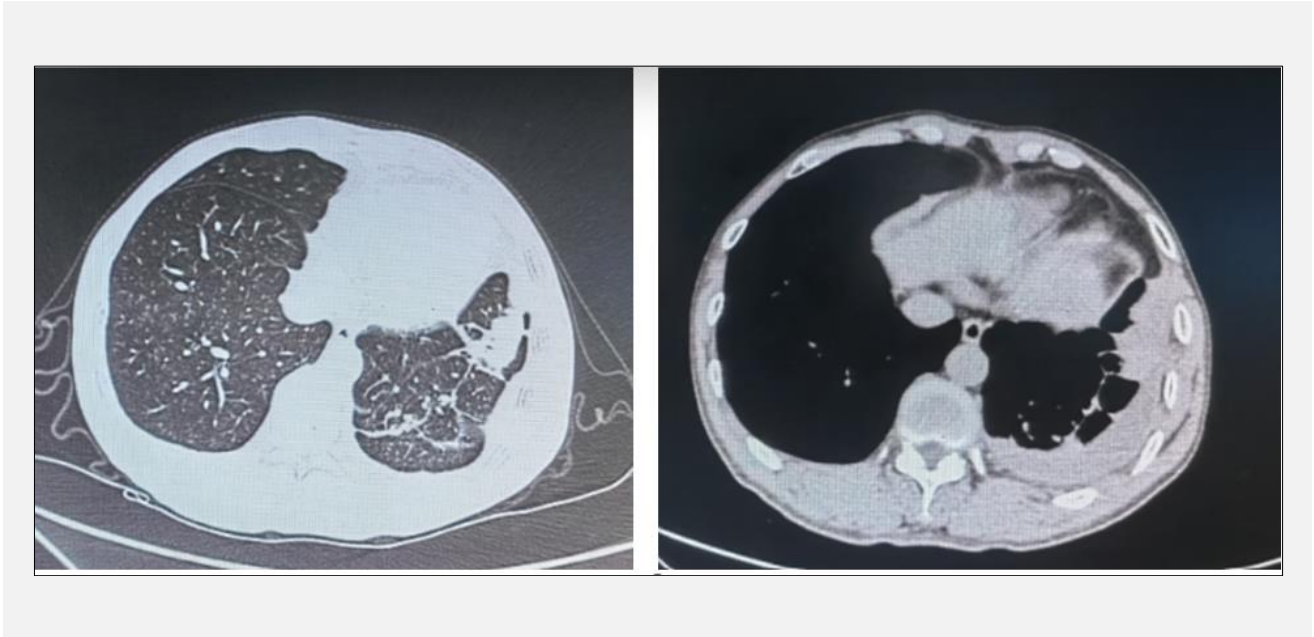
Chest CT scan image from April 12, 2023: High-density shadow in the left lower lung with multiple thick-walled cavitory shadows and left pleural effusion.
